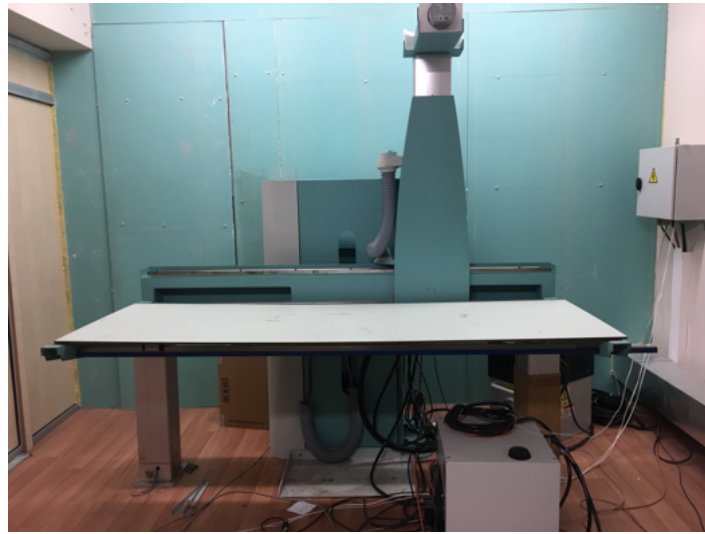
Developed full body X-ray scanner. In this device a TDI detector, high frequency power generator and three servo motor drivers are required to be controlled with iBEX.
